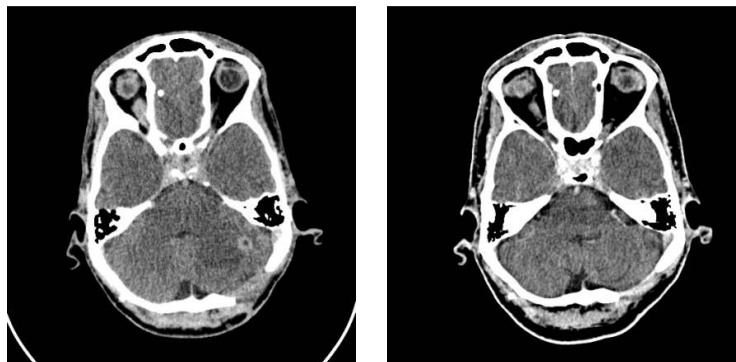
Non-contrast Brain CT scans just before (5 and 6) and after a ventriculoperitoneal shunt placement (7)
